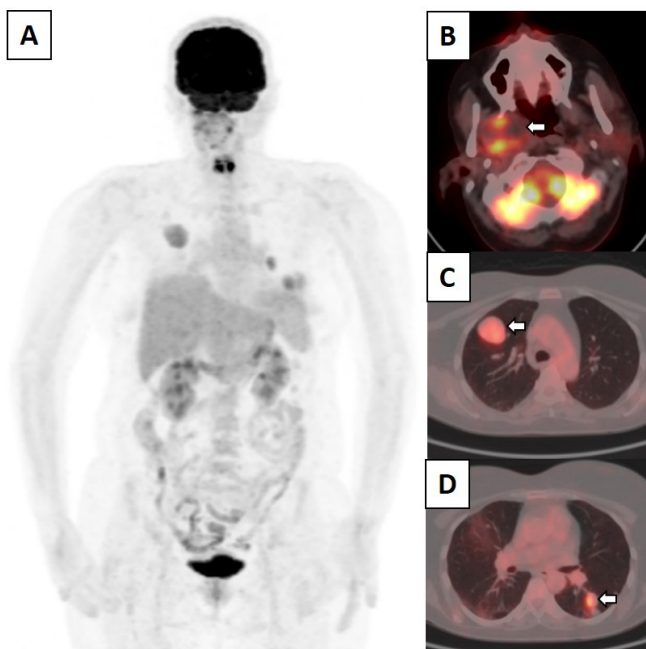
A 51-year-old woman with a history of parotidectomy due to pleomorphic adenoma five years ago was referred for ^{18}F -fluorodeoxyglucose positron emission tomography/computed tomography (^{18}F -FDG PET/CT) due to suspicious lung nodules. Maximum intensity projection (A: MIP) and transaxial fused ^{18}F -FDG PET/CT images showing a hypermetabolic mass located in the right parapharyngeal region (B: arrow), in addition to multiple lung lesions with mild to moderate FDG uptake (C, D: arrows).
